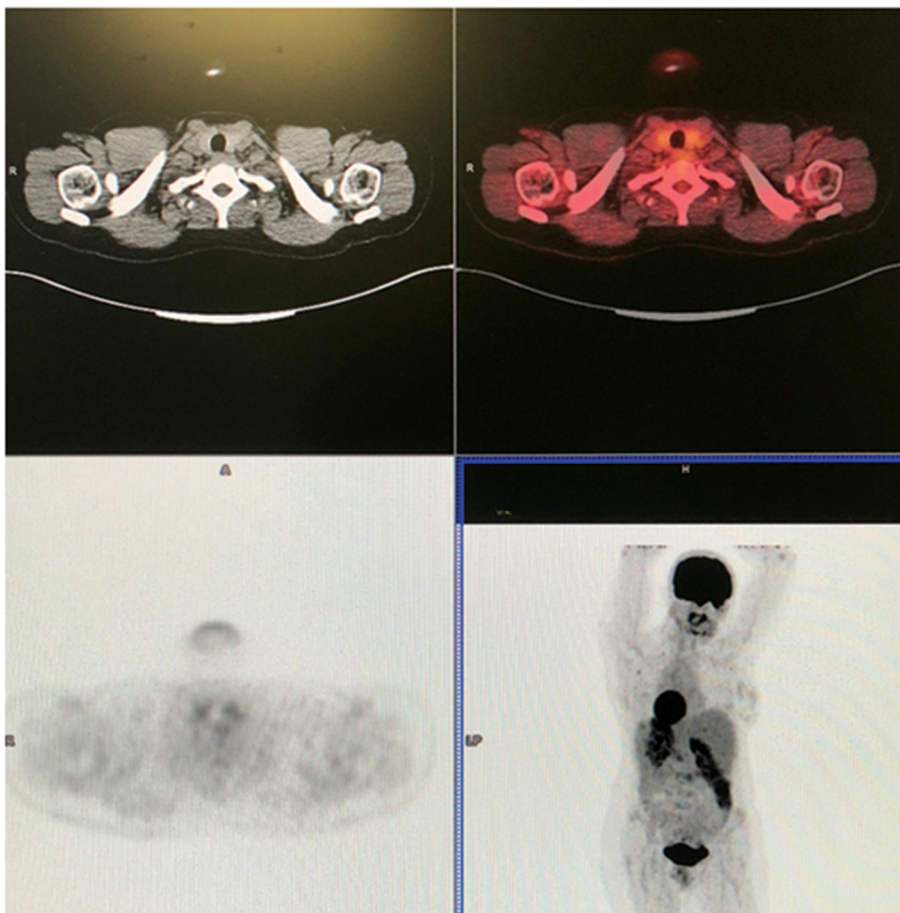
PET/CT with 18F-FDG - axial CT, PET and hybrid images.
